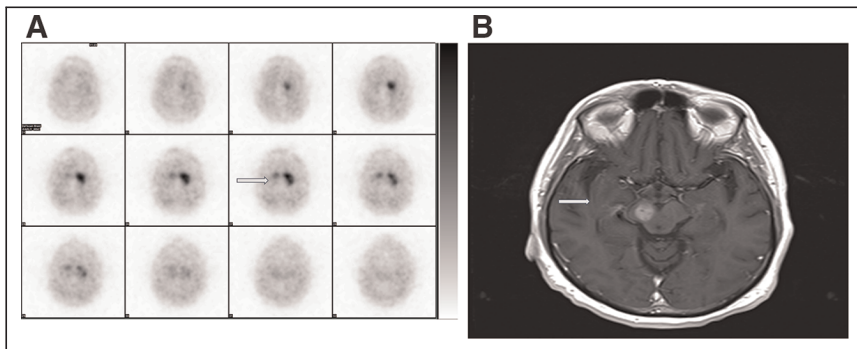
Images of 65-y-old man who had history of low-grade glioma in right midbrain and was being evaluated for right-arm rigidity and tremor. (Left) Axial brain SPECT image showing decreased uptake in right caudate nucleus and no uptake (arrow) in right putamen because of right midbrain glioma. Normal comma-shaped activity is seen in left caudate nucleus and putamen. (Right) Contrast-enhanced T1-weighted brain MR image showing enhancing lesion (arrow) in right midbrain consistent with history of low-grade glioma.
